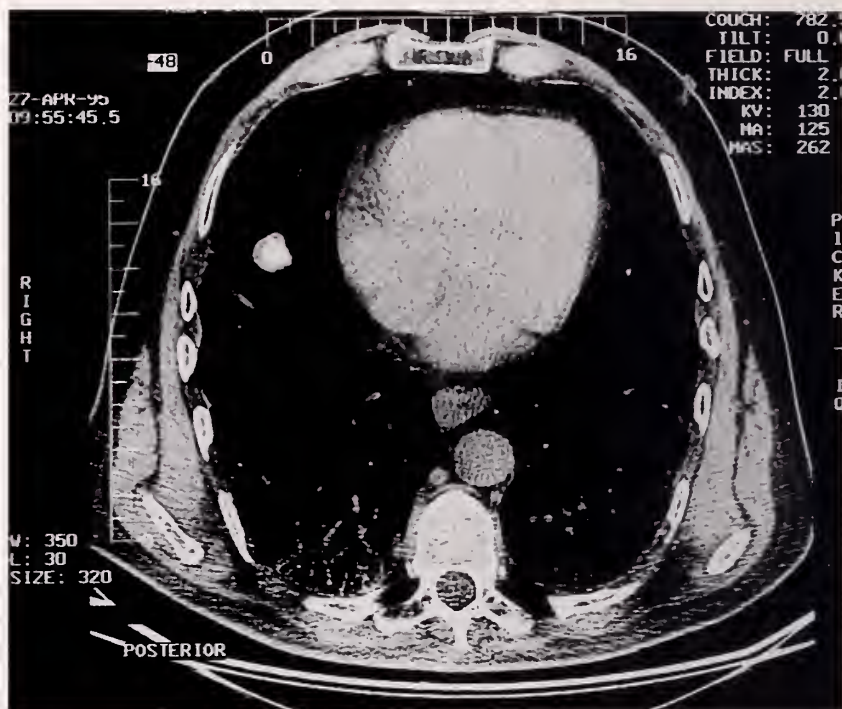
CT scan of the chest confirming the presence of a right lower lobe nodule.
